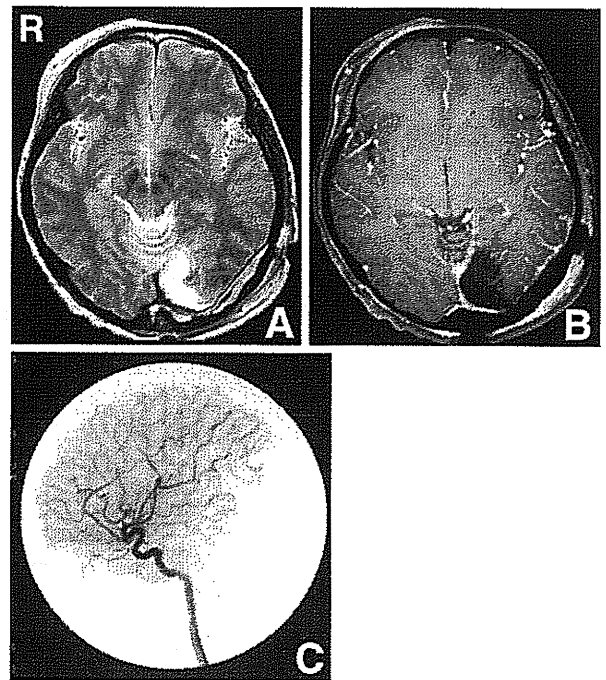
Postoperative T₂-weighted magnetic resonance (MR) image (A), T₁-weighted MR image after administration of contrast medium (B), and selective left common carotid digital subtraction angiogram (C).
